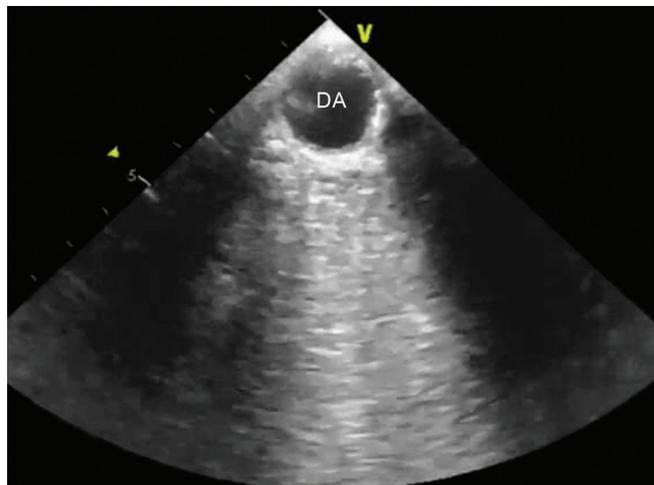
Transesophageal echocardiogram of a sample patient showing an empty left pleural cavity. The apex of the image is formed by the descending aorta and the image artifacts generated by the air inside the left lung occupying the distal part of the image
